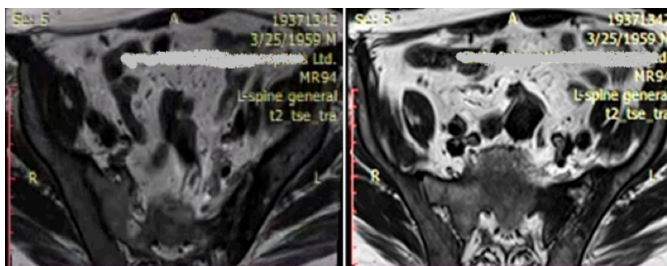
MRI images showing cystic and erosive changes in the left-sided sacroiliac joint.
